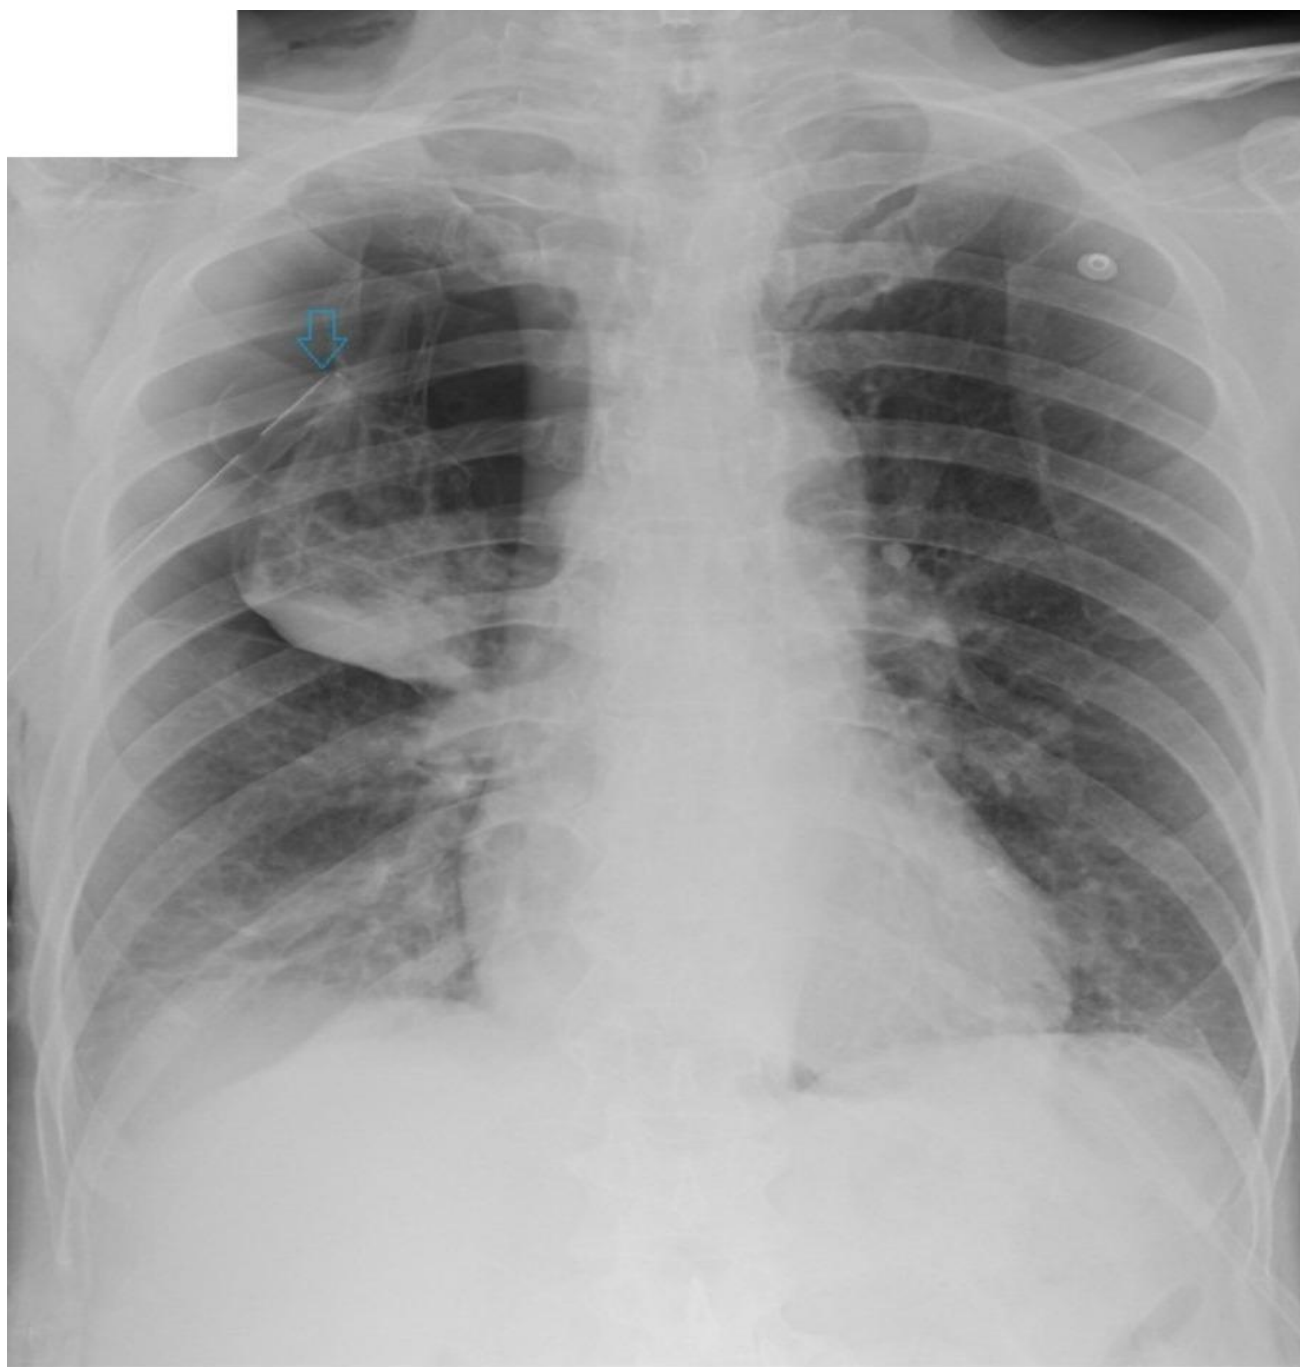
Figure 2 – Chest radiograph showing partial expansion with intercostal drain in situ (Arrow)
